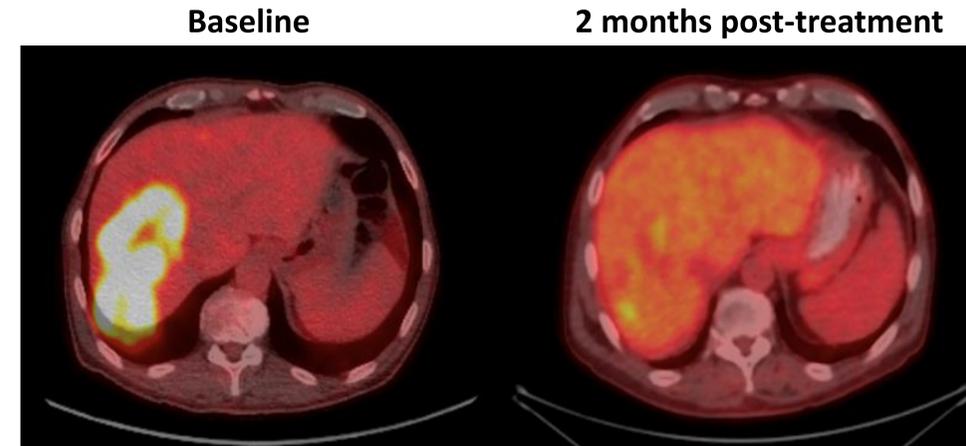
Last radiographic response of treated lesions
